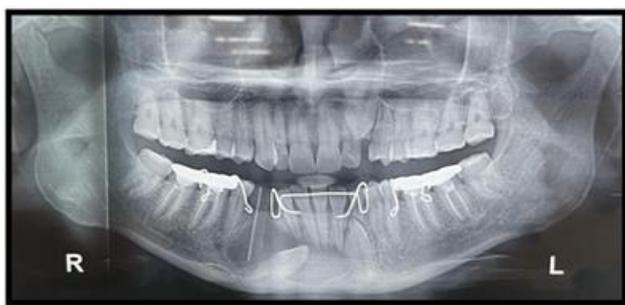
Orthopantomogram One-month post-surgery, follow-up showed significant improvement with a reduced cyst size and increased bone density on radiographs, indicating successful decompression and healing.
